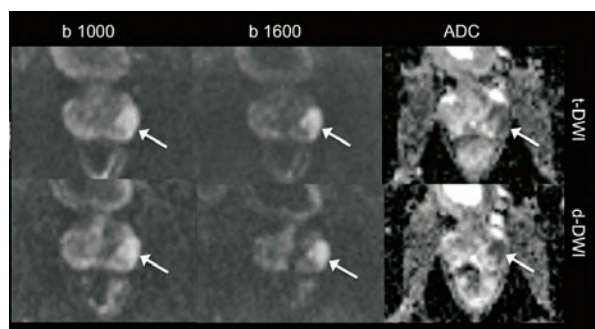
Example of DWI sequences and ADC maps of prostate cancer
